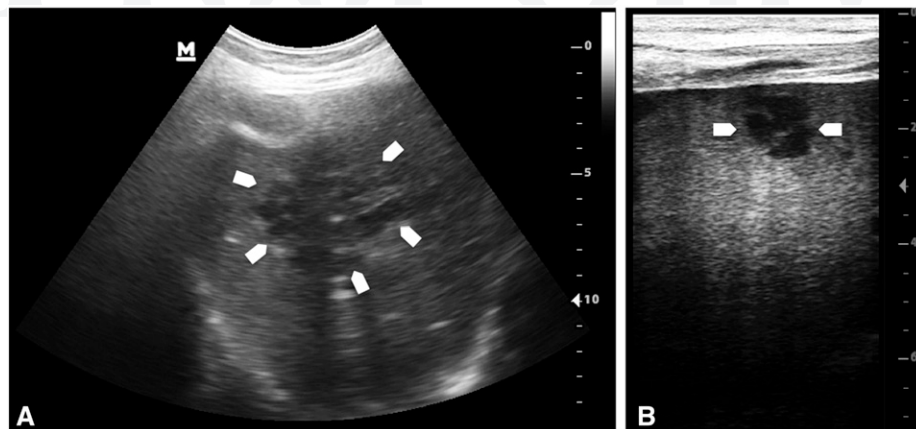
Hypoechoic lesions (arrows) due to melioidosis abscesses in the (A) liver (3.5 MHz convex) and (B) spleen (7.5 MHz linear probe). The hypoechoic lesions in the liver and spleen were frequently septated and/or localized in clusters which may suggest “honeycomb” or “necklace” appearance; because of the low image quality of the point-of-care ultrasound machine, these possibly diagnostic characteristics of the ultrasound images were not included in the analysis.
